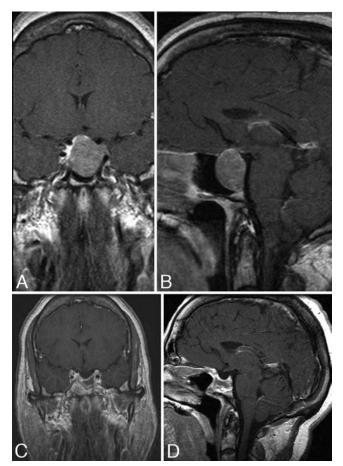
A and B: Sagittal and coronal contrast-enhanced MR images obtained in a 53-year-old woman who presented with clinical signs of acromegaly and a macroadenoma extending into the cavernous sinus and suprasellar cistern. C and D: Six-month postoperative contrast-enhanced MR images revealing postoperative changes but no residual tumor in this patient in whom a biochemical cure was achieved.
